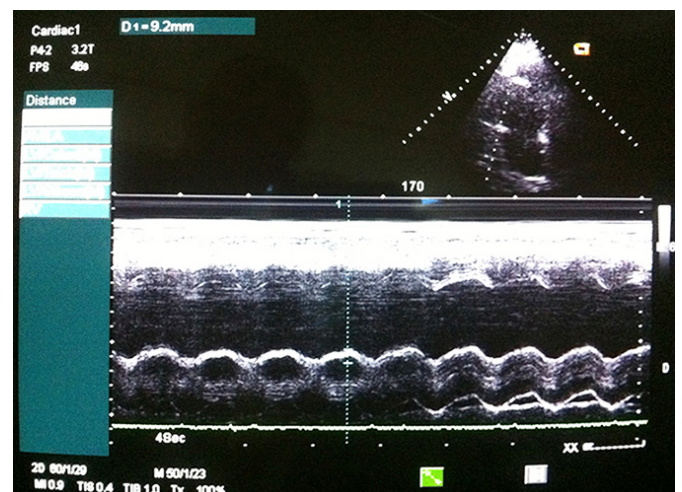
Decreased TAPSE in transthoracic echocardiography.
